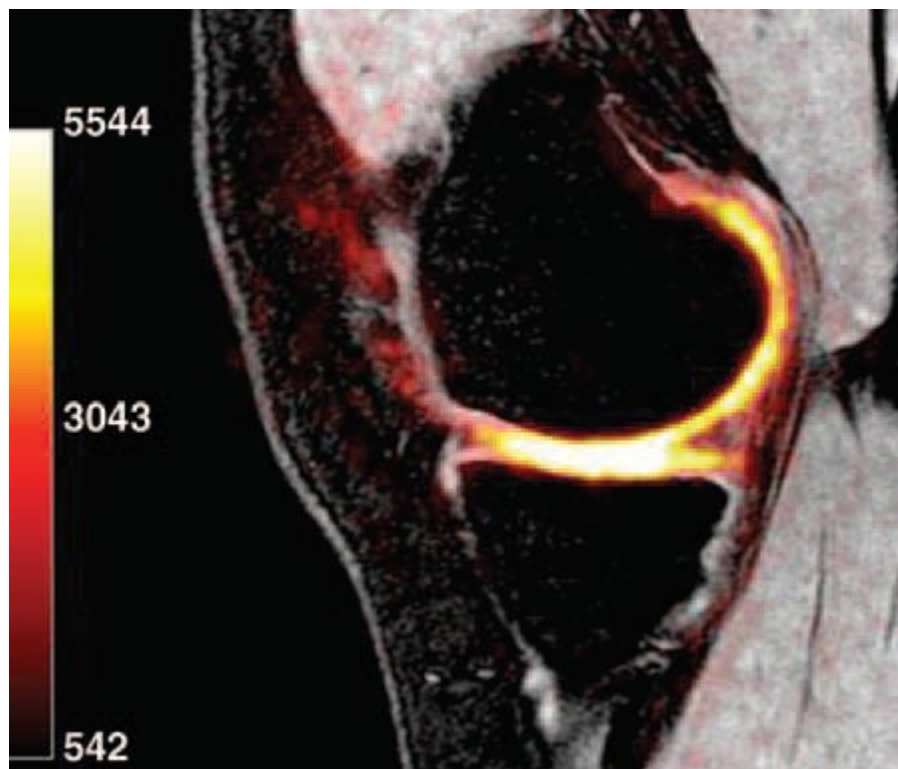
PD-weighted SPGR sequence sodium MR image obtained with a quadrature sodium coil in a normal 20-year-old shows high signal intensity in cartilage at the medial compartment.
